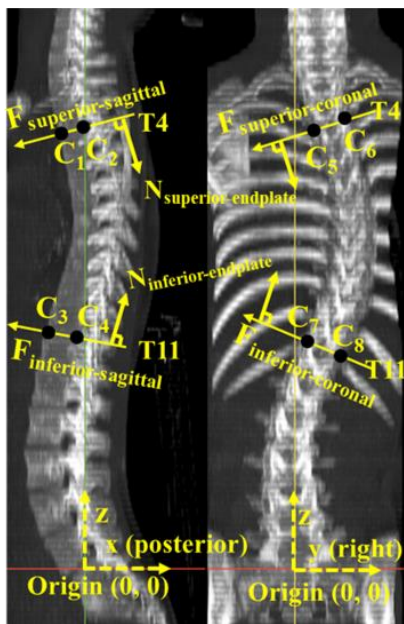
Eight points identification. Eight points in the upper-end vertebra's superior endplate and the lower-end vertebra's inferior endplate were identified in the sagittal and coronal CT images
